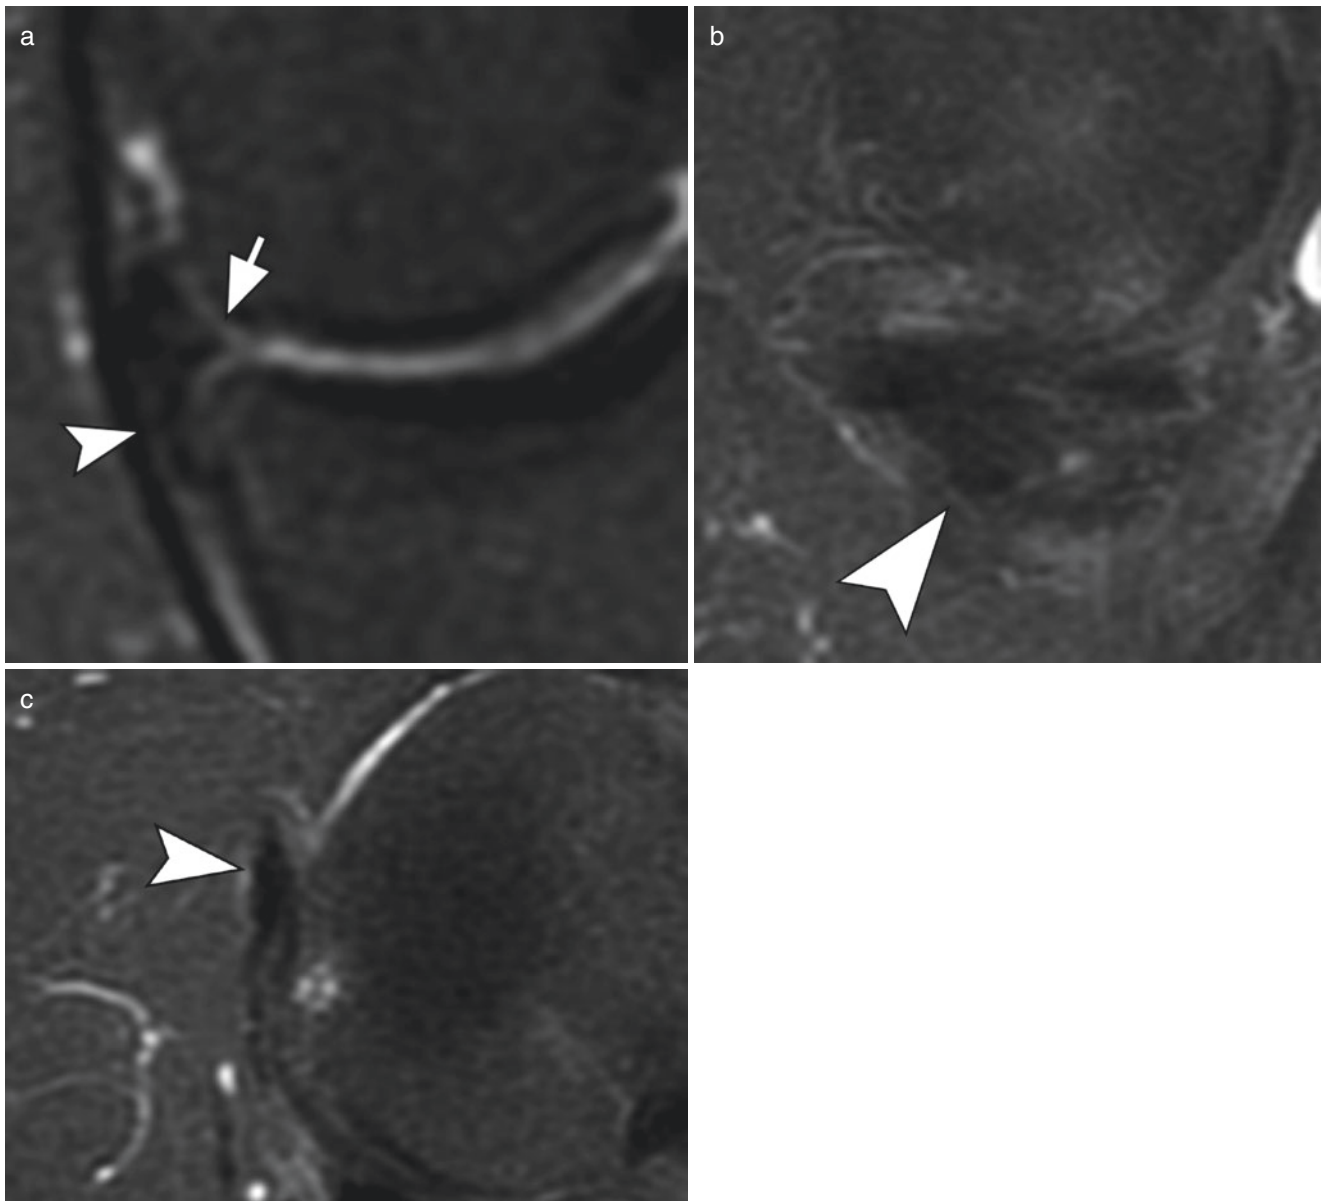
Displaced meniscal tear. (a) Coronal; (b) sagittal; and (c) axial T2-weighted images of the knee with fat suppression. There is a complex tear at the body of medial meniscus with increase in size (arrow). A displaced inferior meniscal flap is associated with this tear (arrowheads)
